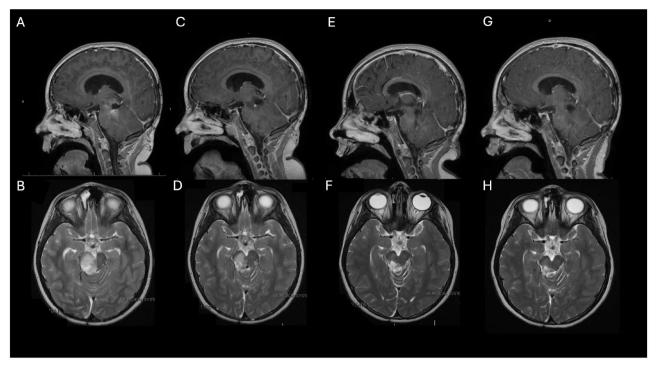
(A and B) Radiographic evidence of progression. Sagittal and Axial view. (C and D): Partial response after 3 months of Larotrectinib. Sagittal and Axial view. (E and F): Near-complete resolution at 15 months. Sagittal and Axial view. (G and H) Most recent imaging at 18 months showing radiographic stability.
